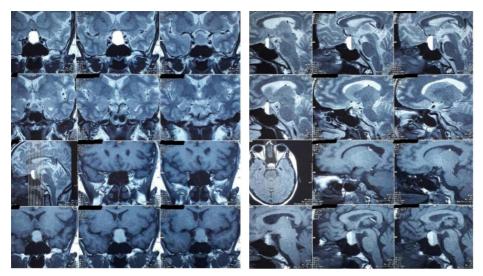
Coronal (a) and sagittal (b) views of brain MRI.
